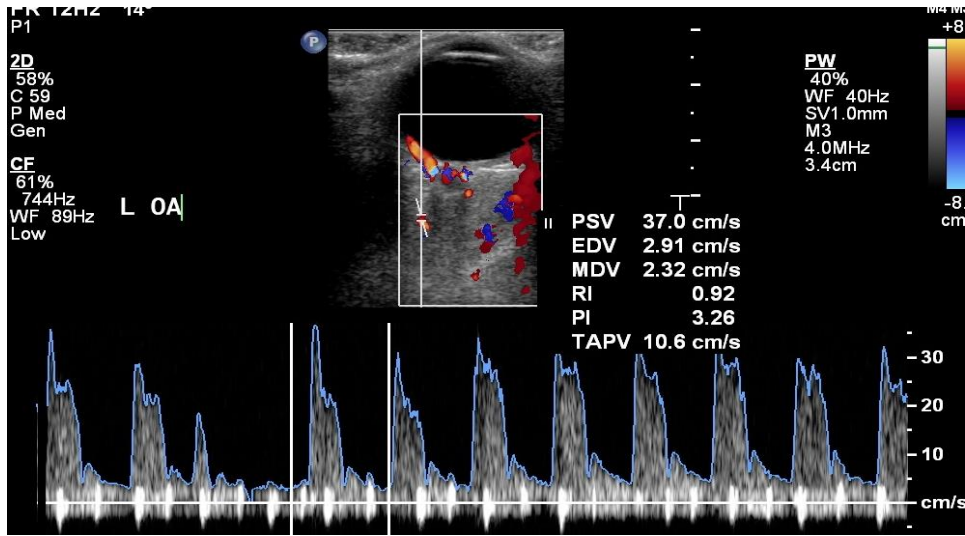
Colour Doppler image of a patient of glaucoma showing (A) the vessels and (B) the corresponding spectral waveforms for the ophthalmic artery (OA)
